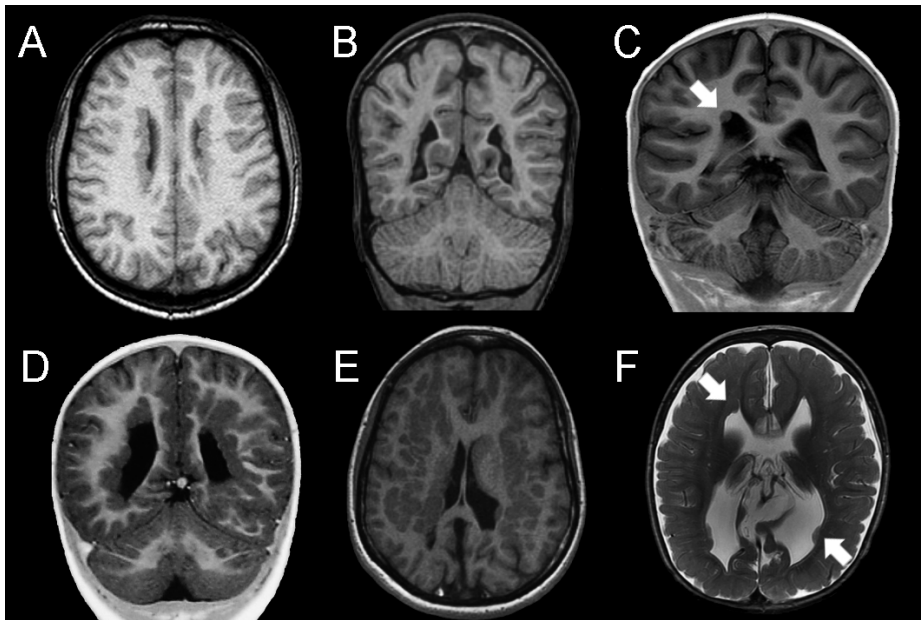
examples of MRI patterns of heterotopia. A: T1-weighted transversal image showing bilateral continuous periventricular nodular heterotopia in a patient with a *FLNA* mutation. B: T1-weighted coronal image showing bilateral, almost continuous periventricular nodular heterotopia in a patient with autosomal recessive *ARFGEF2* mutations. C: T1-weighted coronal image showing a unilateral, isolated periventricular nodular heterotopia (arrow) without known cause. D: T1-weighted coronal image showing extensive bilateral continuous periventricular and white matter heterotopia without known cause. E: T1-weighted transversal image showing bilateral subcortical heterotopia without known cause. F: T2-weighted transversal image showing bilateral isolated periventricular nodular heterotopia in a patient with a meningocele, Arnold Chiari malformation and hydrocephalus.
